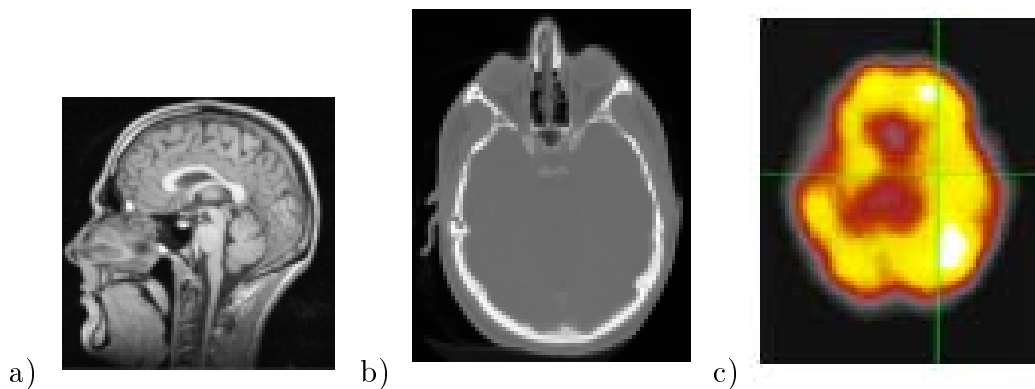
Two-dimensional slices of a) an anatomical MR image, b) an anatomical CT image, and c) a functional (PET) image of the brain.
